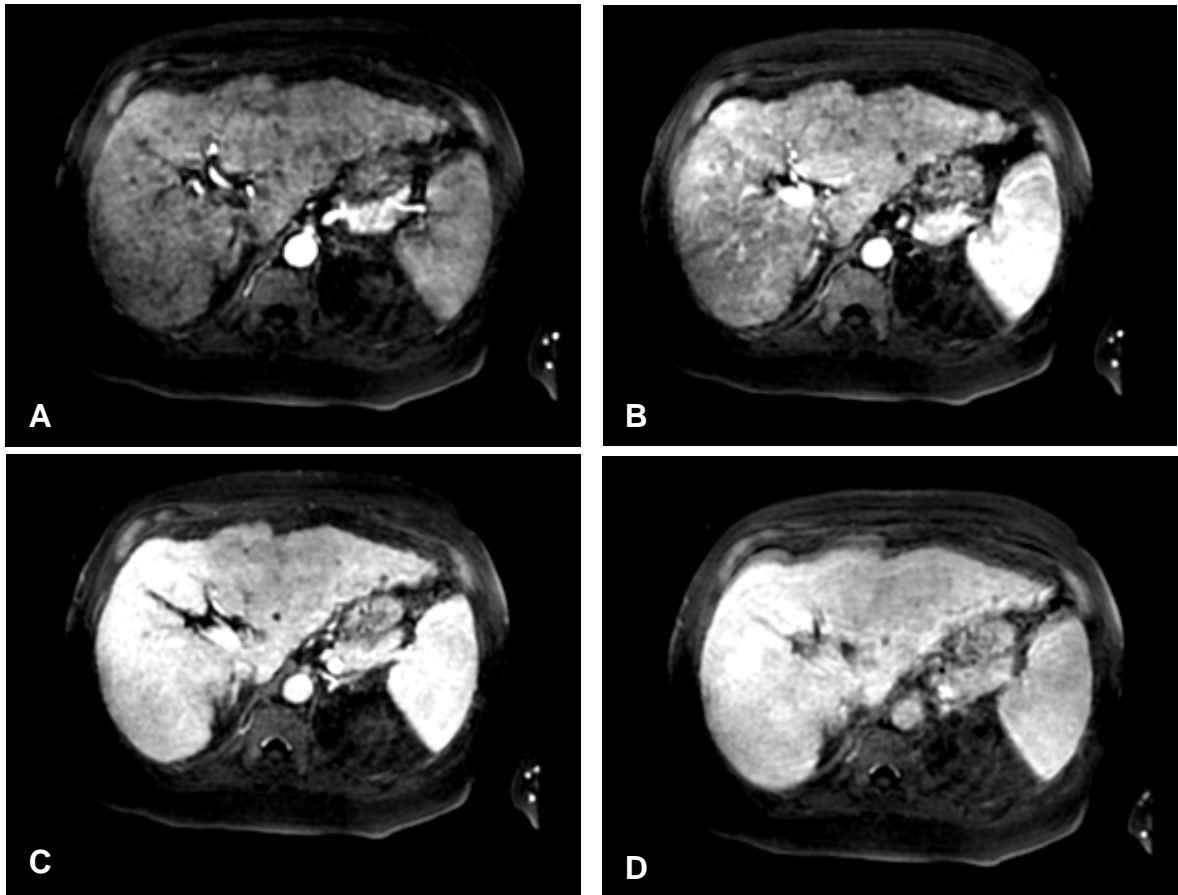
T1-weighted imaging demonstrating the four phases of contrast. (A) Early arterial phase. (B) Arterial phase. (C) Portal venous phase. (D) Delayed hepatobiliary phase (20 minutes post-injection). Note the nodular morphology to the liver contour compatible with cirrhosis. There is a diffuse region encompassing the entirety of the left lobe that demonstrates mild, heterogeneous contrast uptake. On delayed hepatobiliary phase imaging, this region shows decreased uptake and is compatible with a diffuse infiltration hepatocellular carcinoma.
